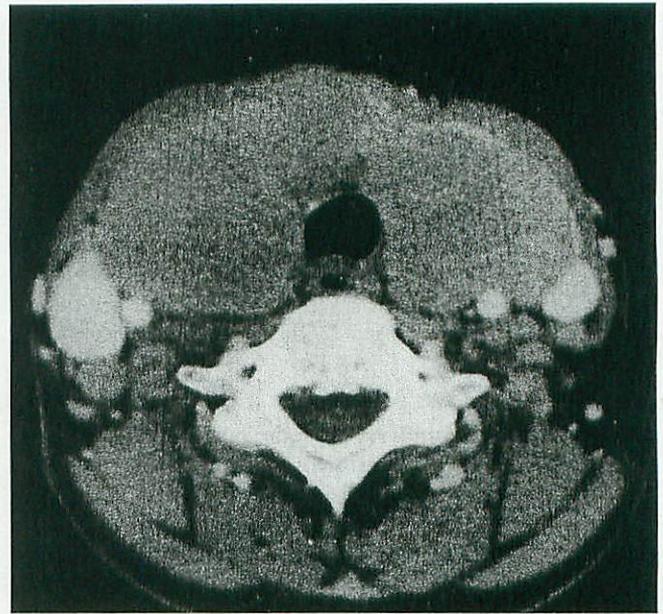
Postcontrast computed tomography (transverse imaging) showing diffuse swollen thyroid gland with homogeneous contrast enhancement inside the lesion (non-Hodgkin's lymphoma of the thyroid gland, diffuse, large cell, B cell, 55-year-old woman).
